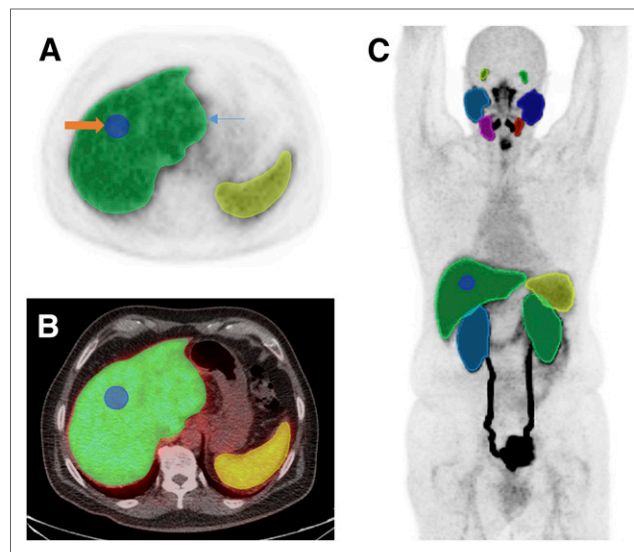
(A) axial ^{18}F -DCFPyL PET image through upper abdomen including liver and spleen showing whole-organ VOI (blue arrow) and 3-cm-sphere VOI in right lobe of liver (orange arrow). (B) Corresponding axial fused ^{18}F -DCFPyL PET/CT images. (C) Representative organ VOIs displayed on maximum-intensity-projection image.
